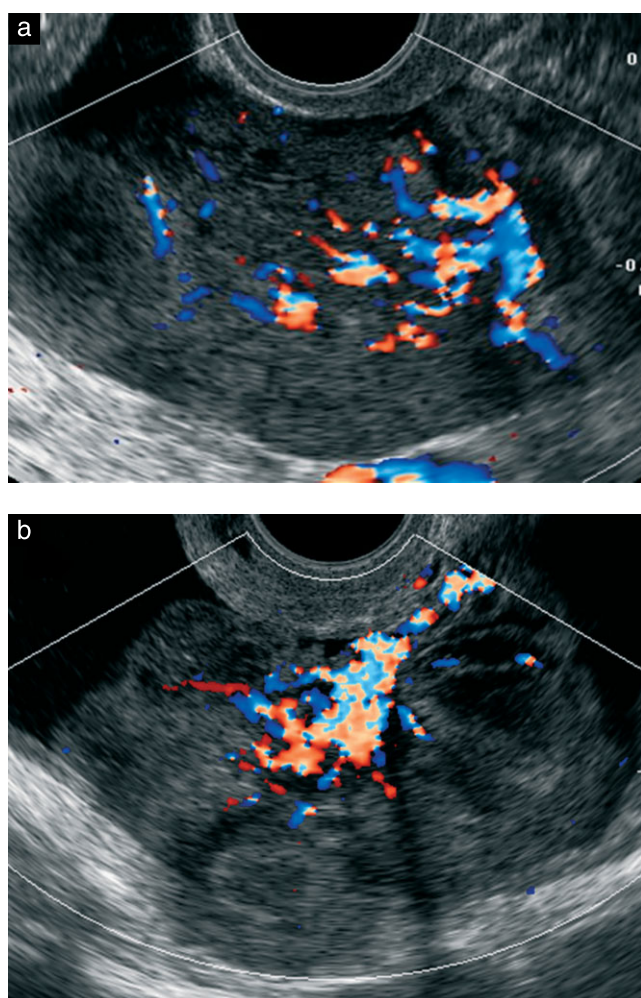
Color Doppler images from two patients with ovarian metastasis from a gastric tumor. A main vessel exhibiting a tree-shaped morphology, and penetrating from the periphery into the central part of the ovarian mass, is visible.
